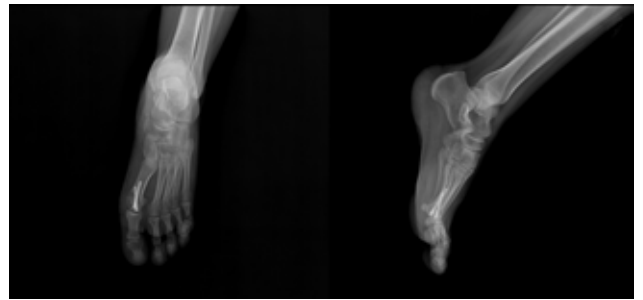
Postoperative radiographic images of a 33-year-old male patient with HV treated with cannulated screws.
